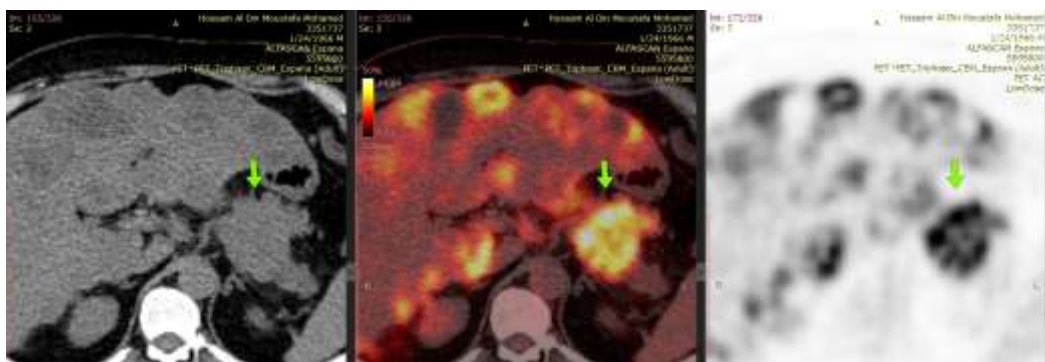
Non-contrast low dose CT, fused images and PET axial cuts demonstrates FDG-avid irregular exophytic pancreatic body mass
